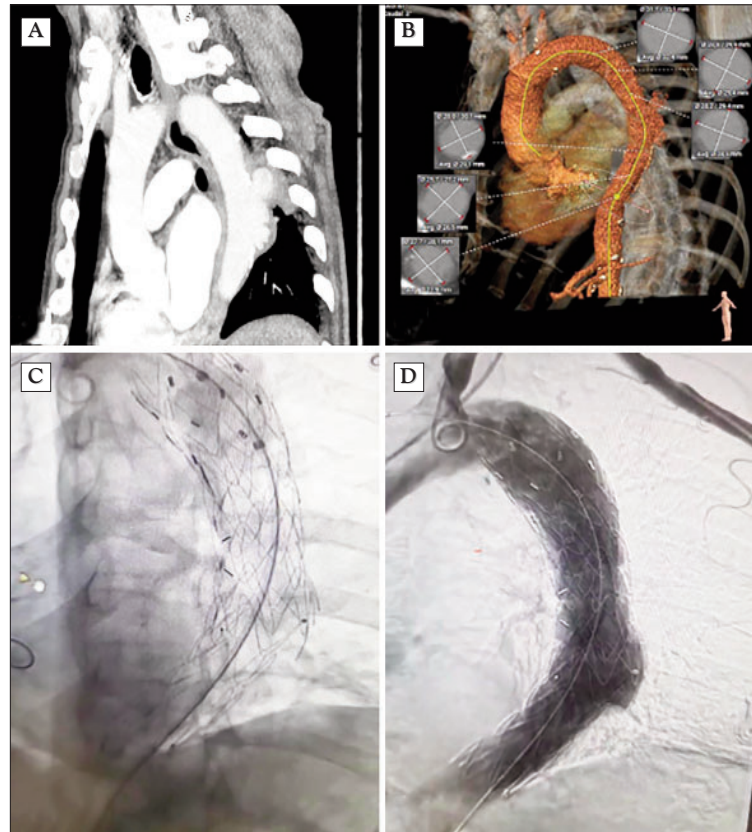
Case Report VI imaging: (A) - 3D-CT reconstruction of penetrating aortic ulcer (PAU) of descending aorta; (B) - 3D-CT TEVAR planning; (C, D) – Angiographic image of optimal TEVAR result.
